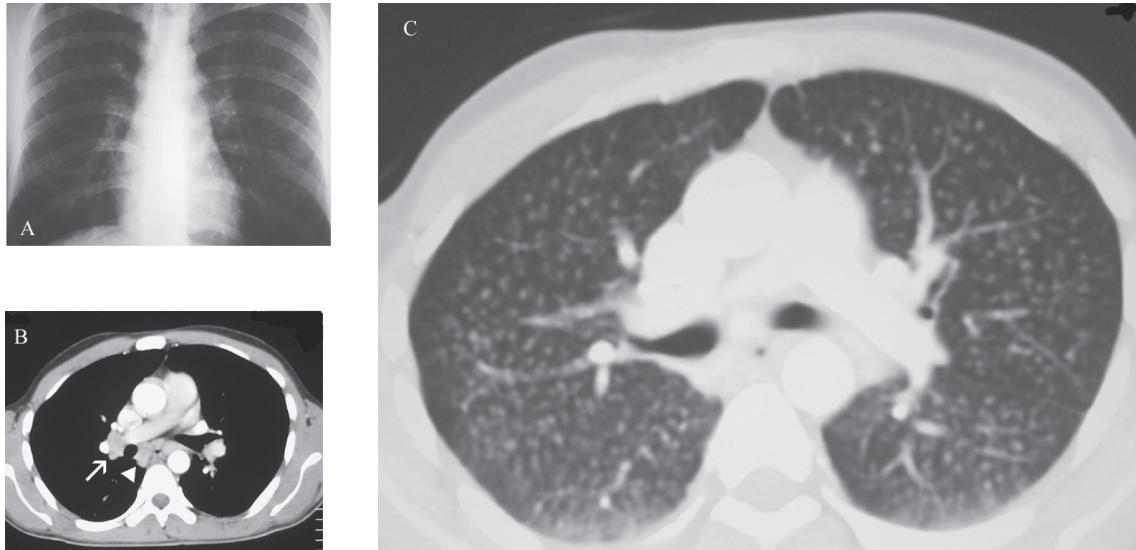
A) Posteroanterior chest X-ray; B) hilar lymph nodes (white arrow) and mediastinal lymph nodes (arrowhead) in CT; C) millimetric nodular lesions in CT.
